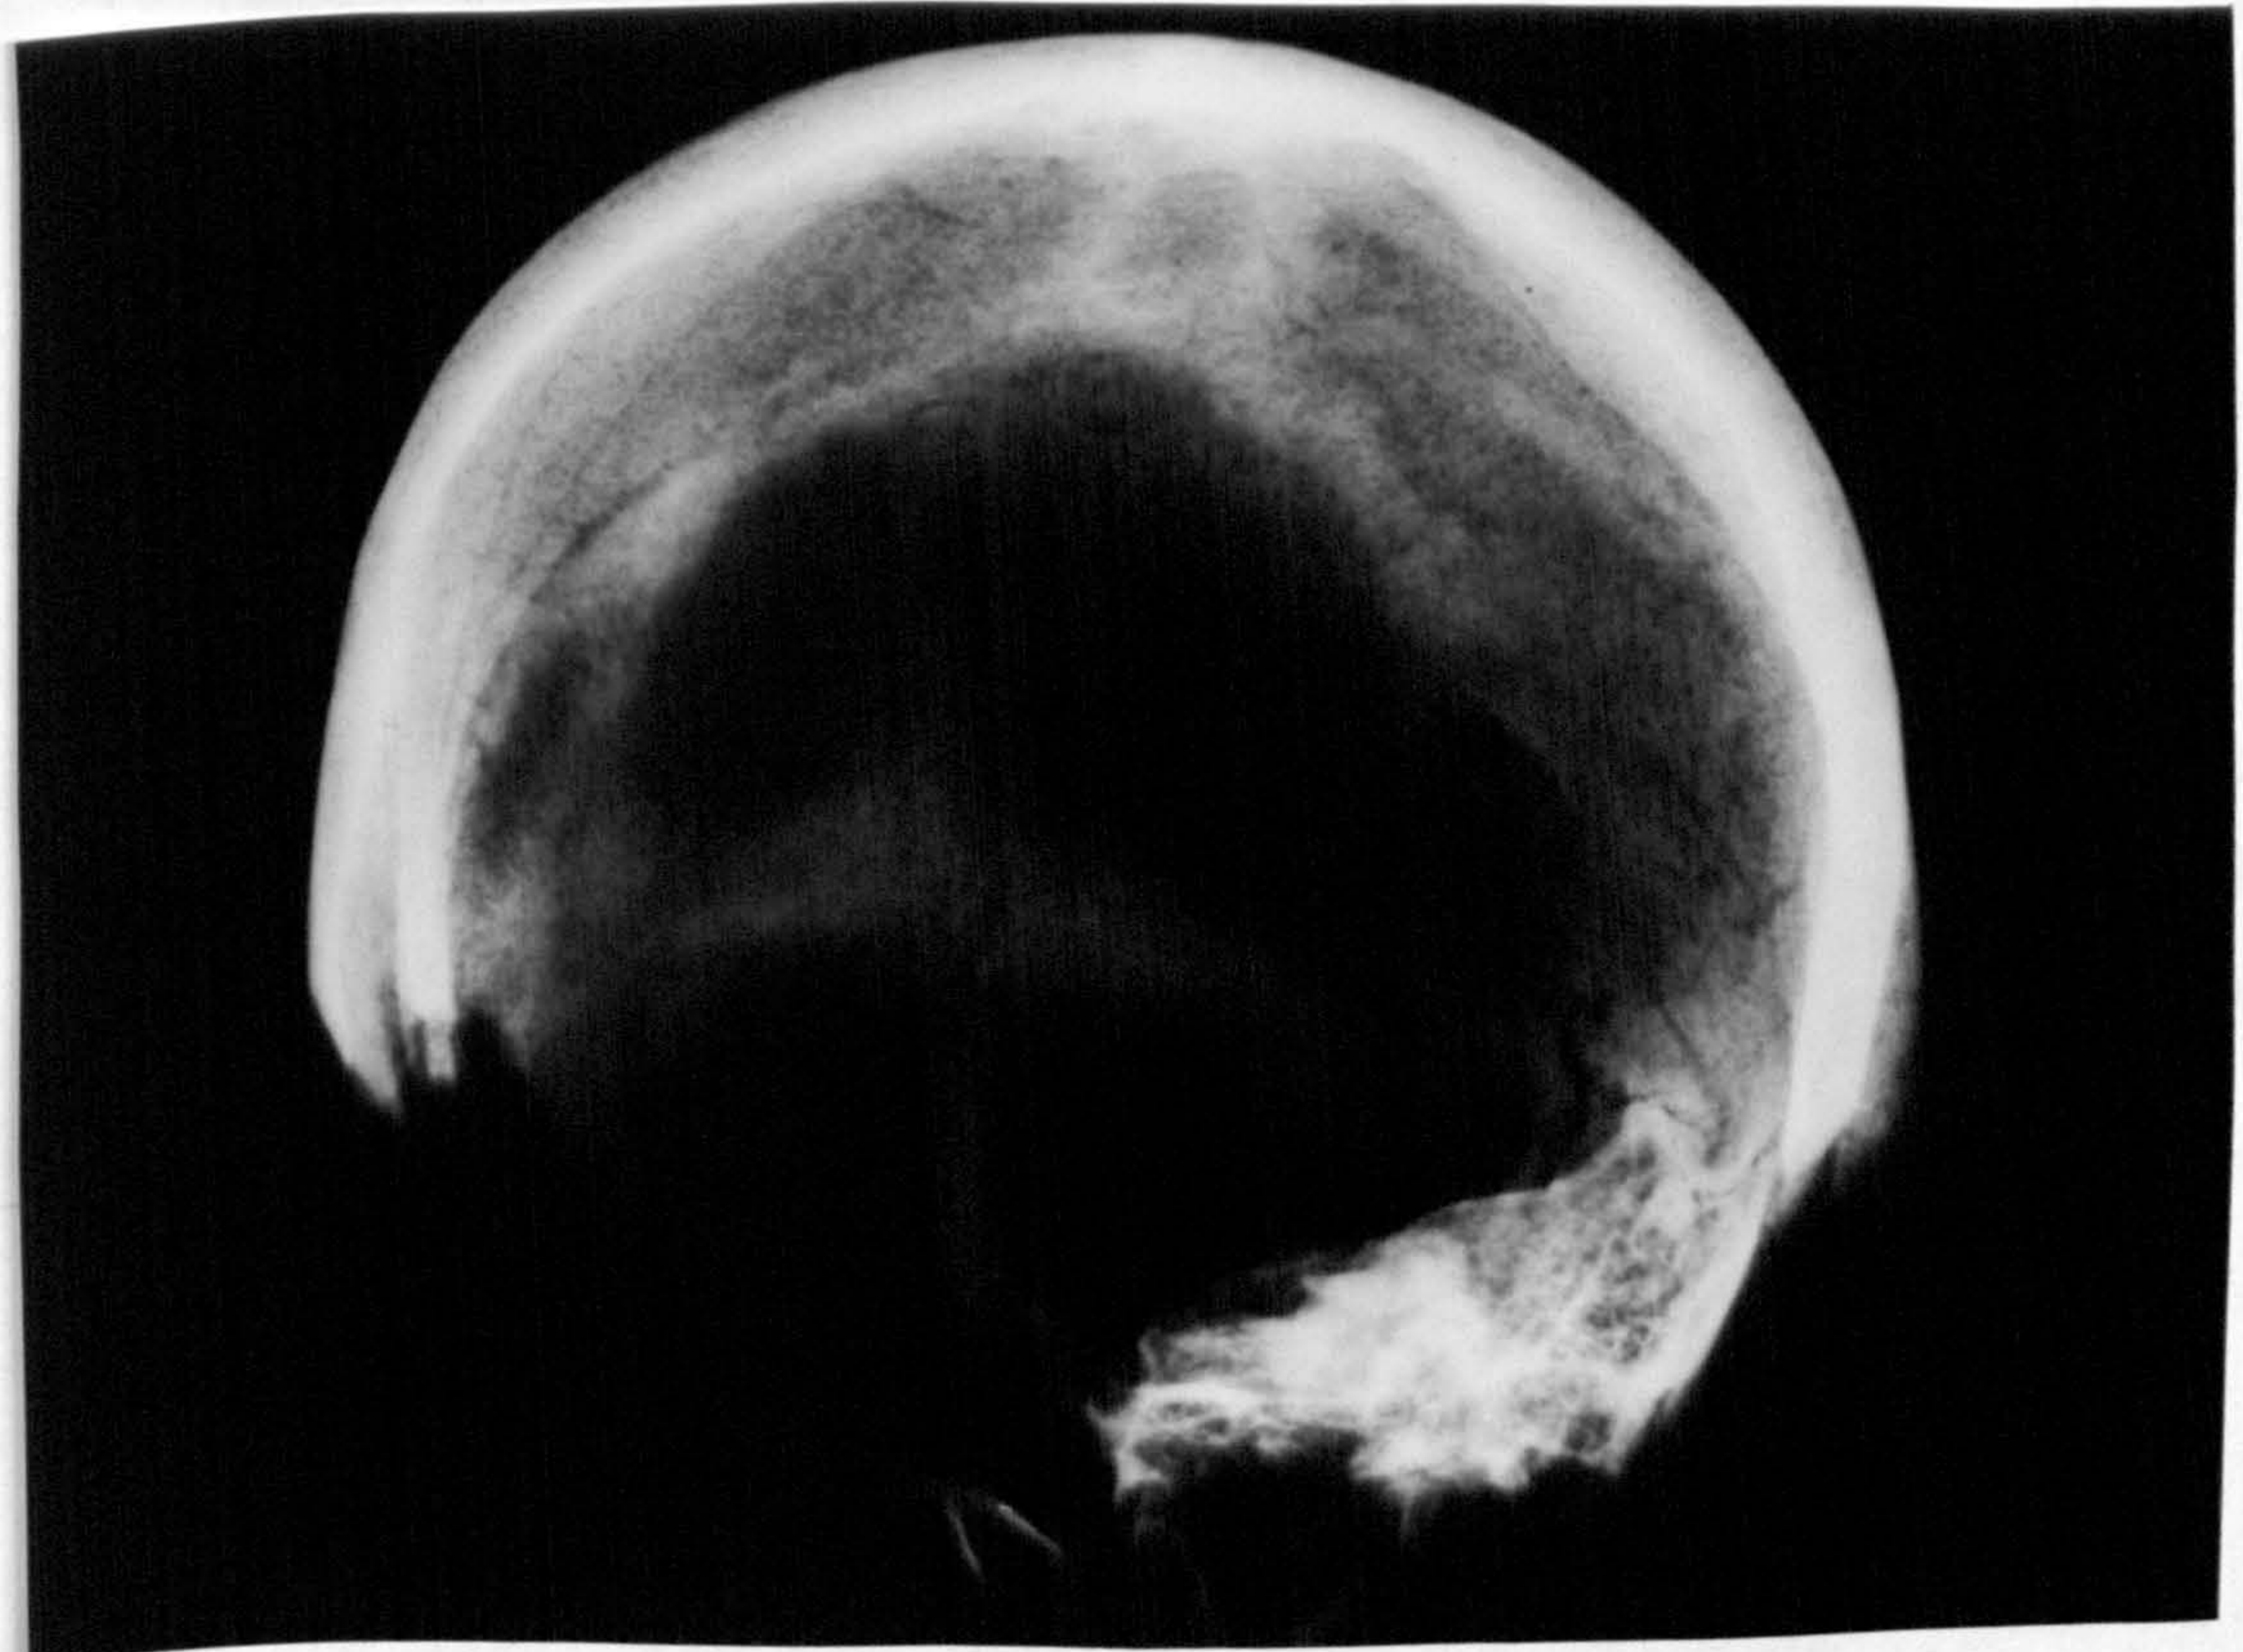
Example of antero-posterior (AP) x-ray used in the study
